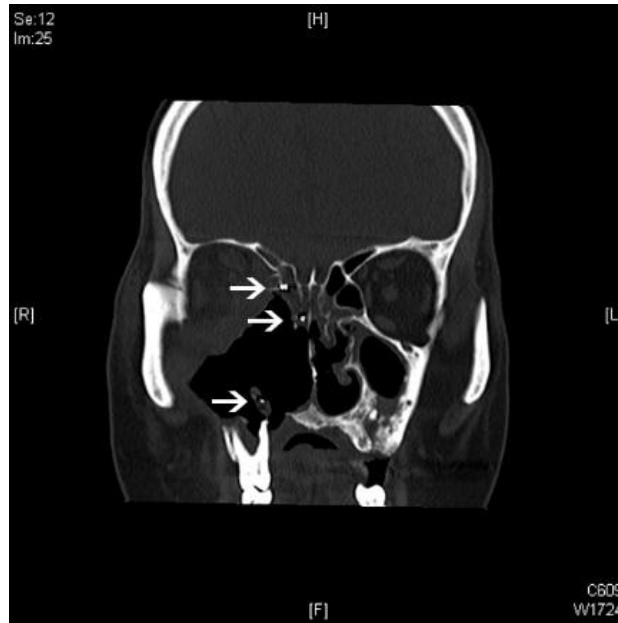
Computed tomography scan of the head in coronal cut.
